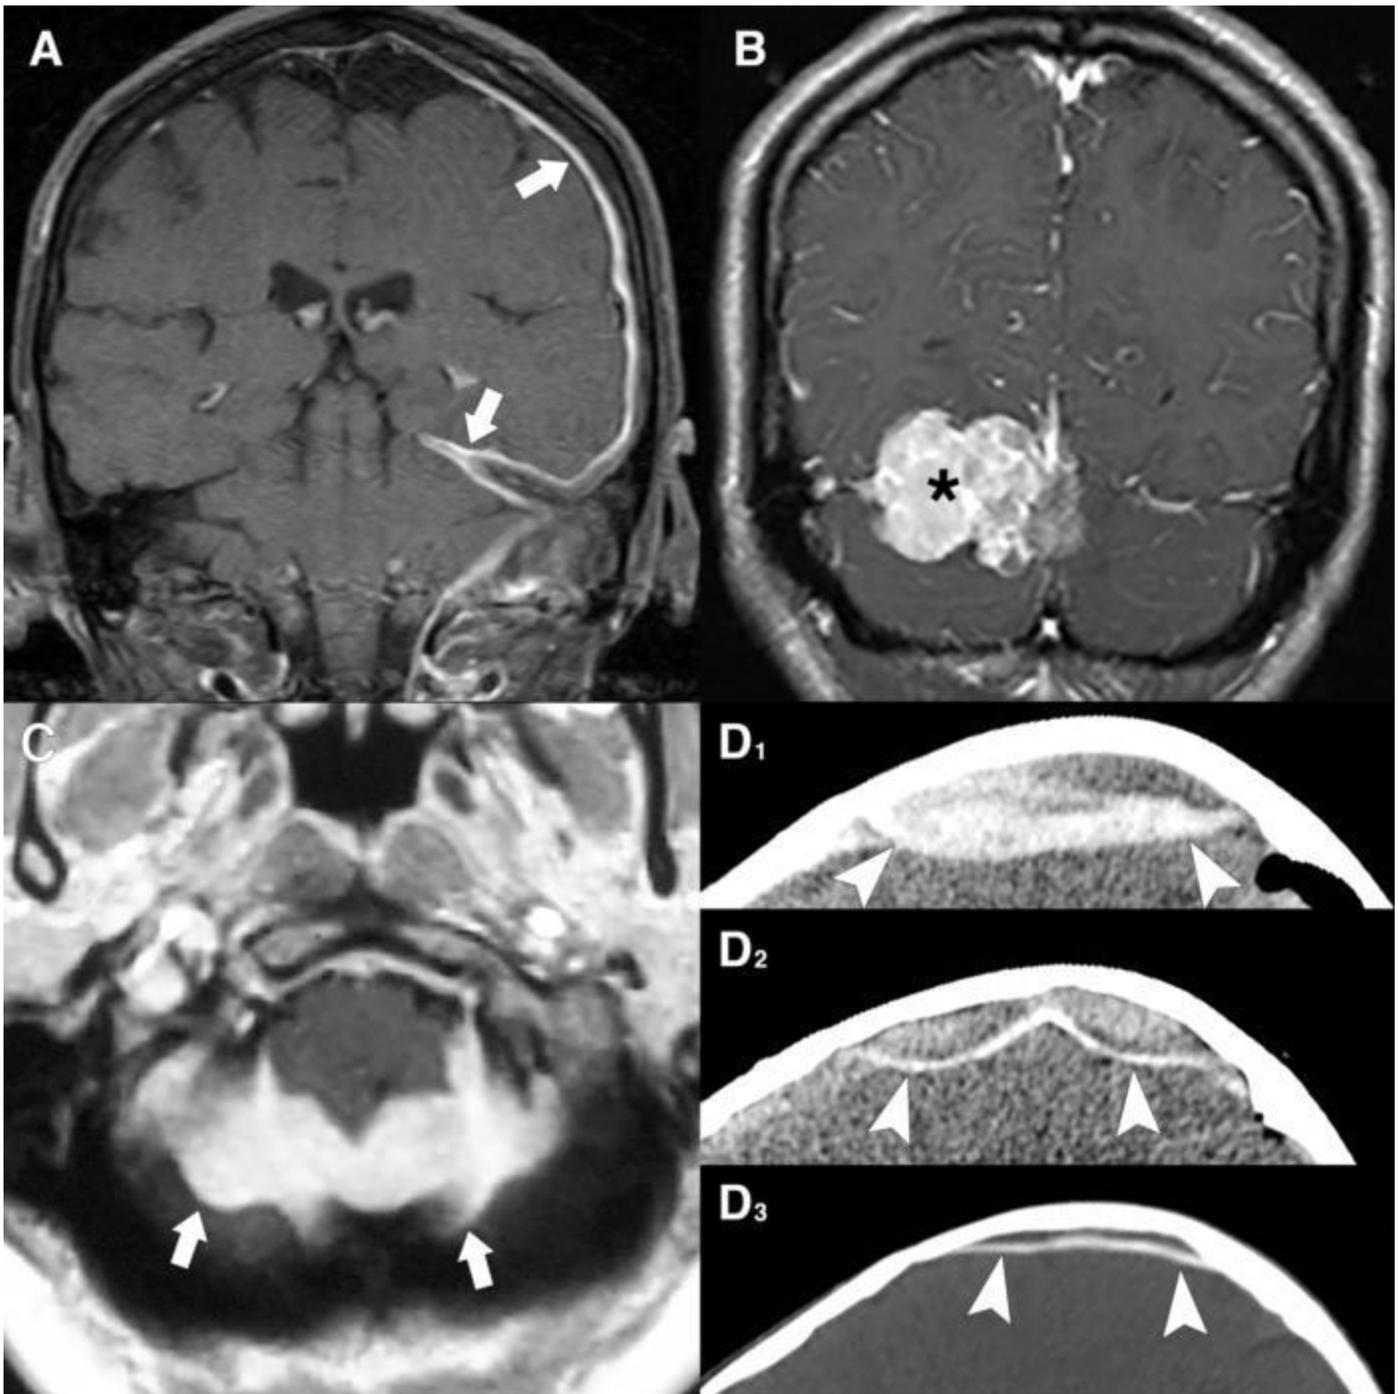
Figure Legend: Examples of select entities that may affect the dura. (A) Coronal post-contrast fat-saturated T1 shows extensive dural thickening and enhancement of a patient with granulomatosis with polyangiitis (arrows). (B) Coronal post-contrast T1 in a different patient with a solitary fibrous tumor shows a mildly heterogeneous, avidly enhancing mass (asterisk) centered in the right tentorium. (C) Axial post-contrast T1 in a different patient with Rosai-Dorfman disease demonstrates thick enhancing tissue in the posterior fossa (arrows). (D) Axial noncontrast CT images at various timepoints in a different patient show progressive dural calcification following an epidural hematoma (arrowheads).
